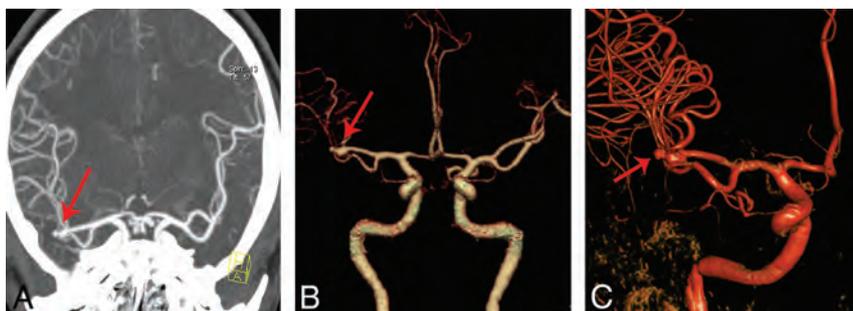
An 80-kVp cerebral CTA with 30 mL of contrast agent in a 45-year-old man. Maximum-intensity-projection image (A) and a volume-rendered digital subtraction CTA image (B) show an aneurysm in the right middle cerebral artery (red arrow), which is confirmed by 3D-DSA (C).
